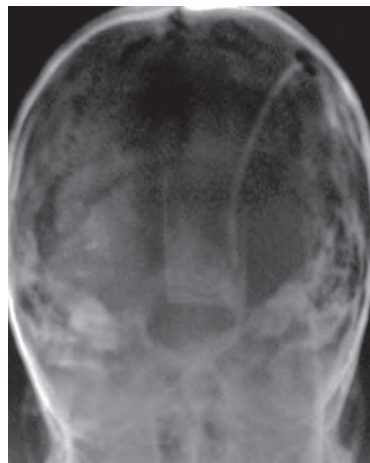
X-ray skull Towne's view demonstrating bony erosion of the medial petrous bone
